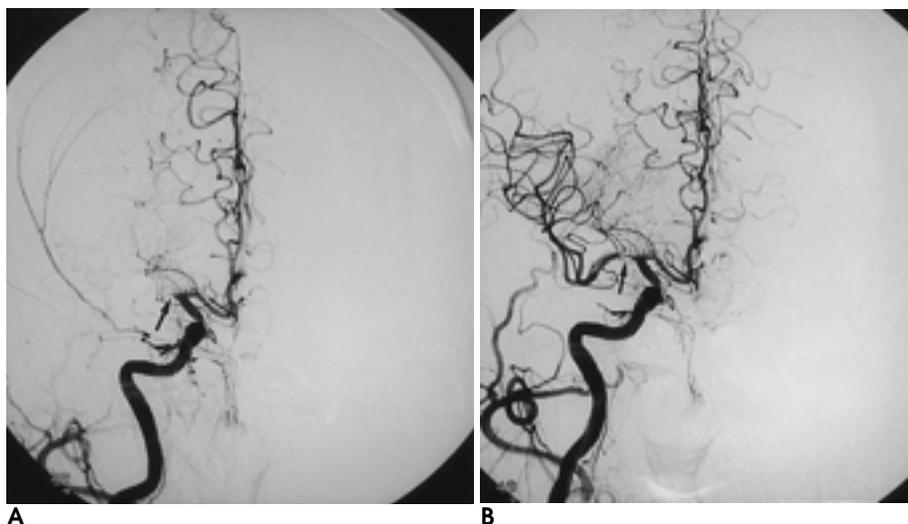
A 73-year-old woman received thrombolytic therapy 4 hours after onset of hemiparesis and dysarthria. Initial frontal projection on the right common carotid angiogram shows complete occlusion of the proximal middle cerebral artery (arrow) (A). After arterial infusion of 1,000,000 IU of urokinase, there is complete recanalization with residual stenosis (arrow) in the M1 segment (B). Immediate follow-up CT shows normal findings (not shown). Her SSS decreased from 11 point before treatment to 1 point 8 days after thrombolytic therapy.
